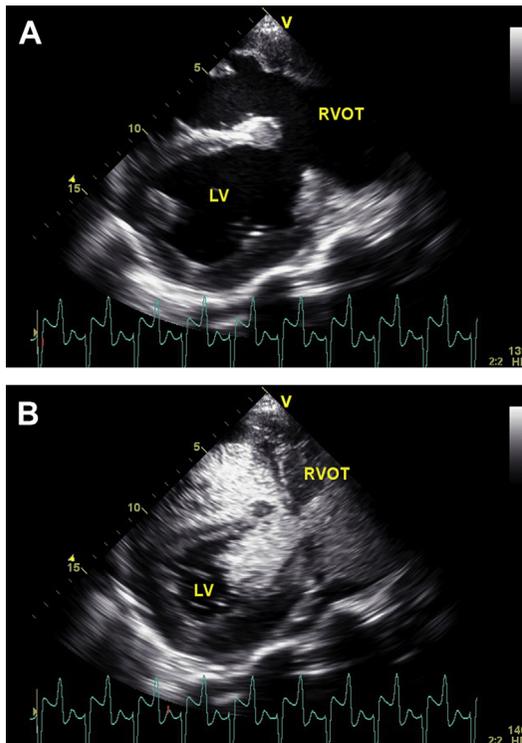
2D B-mode recording in a right parasternal short-axis view, below the level of the mitral valve. (A) A large subpulmonic VSD in its typical location, connecting the LV with the RVOT. (B) Image recorded in the same imaging plane, captured during a saline contrast (bubble) study. There is intense saline contrast present in the RV and the RVOT, extending through the defect into the LV, indicating diastolic right-to-left shunting across this large defect.
